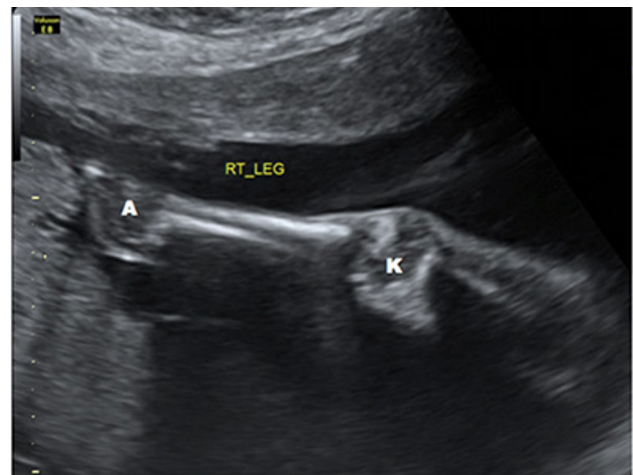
Fetal sonogram shows muscle atrophy (sarcopenia) of right leg. A, fetal ankle; K, fetal knee.
